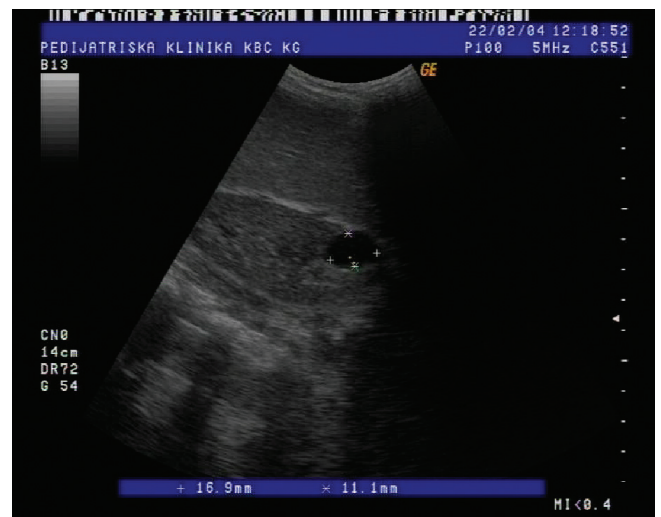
Ultrasound of the left kidney with cysts and large spleen.
